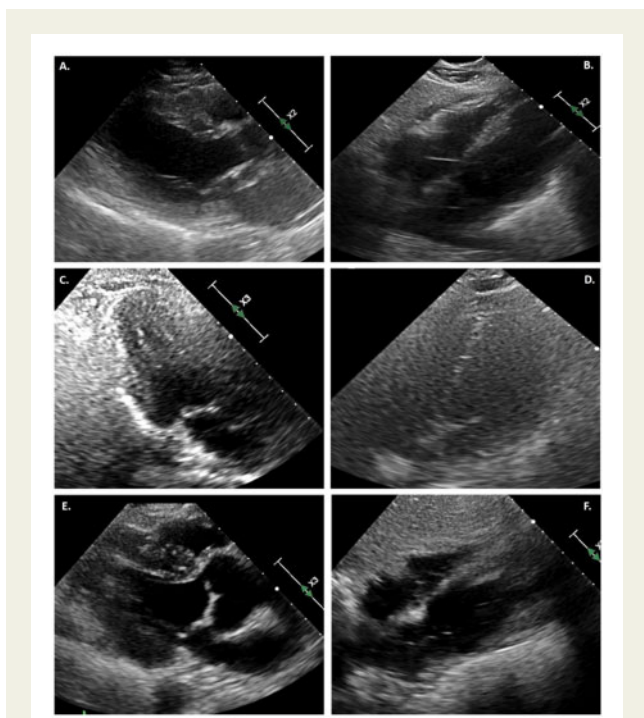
(A) TTE in parasternal long-axis view at end systole, demonstrating severe LV systolic dysfunction. (B) Subcostal view with small pericardial effusion. (C) Repeat echocardiogram on day 6 in three-chamber view at end systole, demonstrating normal LV function. (D) Resolution of pericardial effusion on hospital day 6. (E) TTE at day 35, showing continued normal systolic function in the parasternal long-axis view at end systole. (F) No further pericardial effusion on subcostal view.
